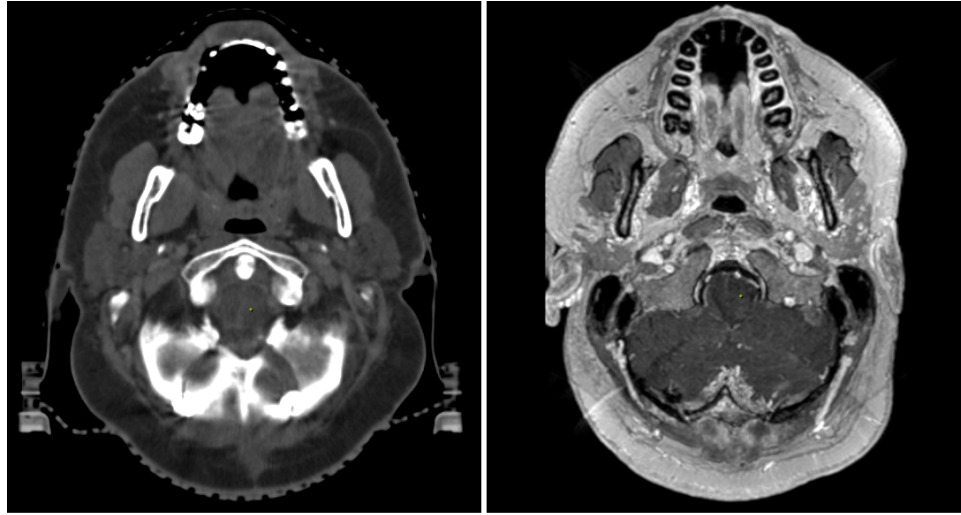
(Left) Magnetic Resonance Imaging (MRI) image compared with a Computed tomography (CT) image (right) for a same patient. Notice that MRI is better suited to distinguish soft tissues than CT, which is more appropriate to visualize dense tissues such as bones. [This image is used under permission of the Hospital Universitario Puerta de Hierro Majadahonda, Madrid, Spain].
